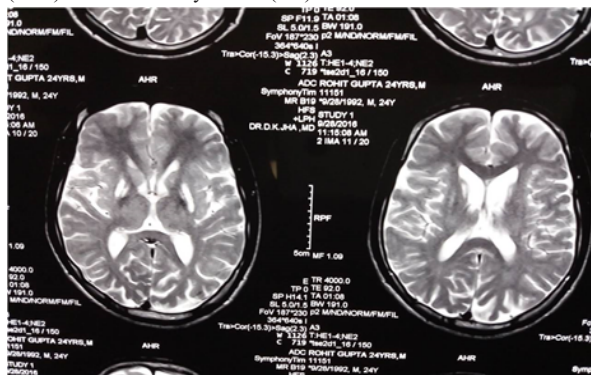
MRI Brain: T2W- hyper-intense areas in putamen & caudate bilaterally
